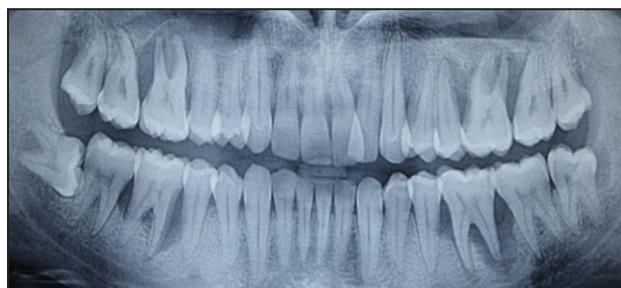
Pre treatment orthopantomograph.
